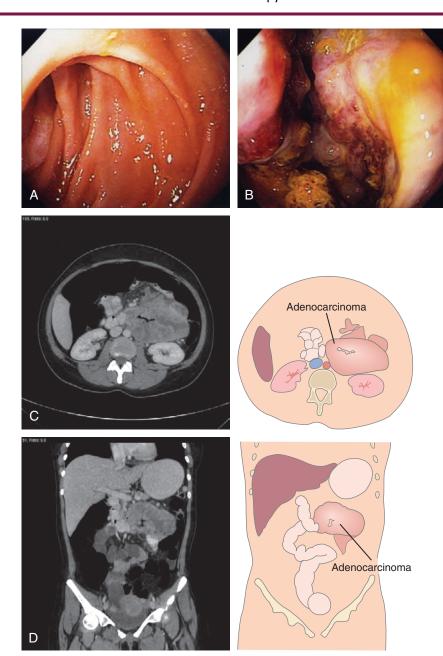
ADENOCARCINOMA A, At the junction of the second and third duodenum, a glimpse of abnormal tissue is shown. B, A circumferential ulcerated mass lesion is identified with further advancement. C, D, CT images show the extensiveness of the mass.
